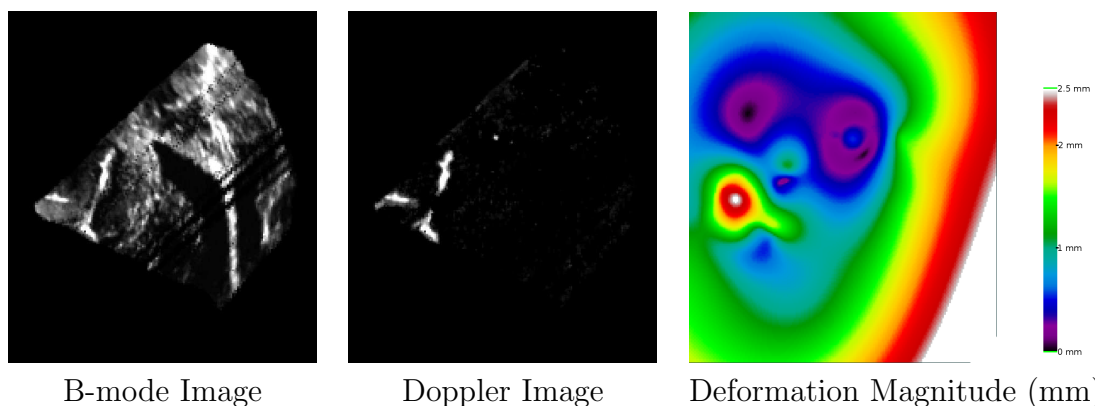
Images from Patient 4 (see Table 3-4) showing a coronal slice from the reconstructed US image (Left), the Doppler US vessel image (Middle), and the magnitude of non-linear deformation recovered after the linear registration phase (Right). This reveals that significant non-linear deformation occurs even prior to dural opening. The magnitude of non-linear deformation recovered from MR to US registration was very high close to the Doppler vessels with the maximum recovered deformation of 2.5mm and the minimum of 0.006mm. Note that the deformation field can be high in the borders of the image where there are no vessels to “lock-down” the amount of deformation in these regions.
